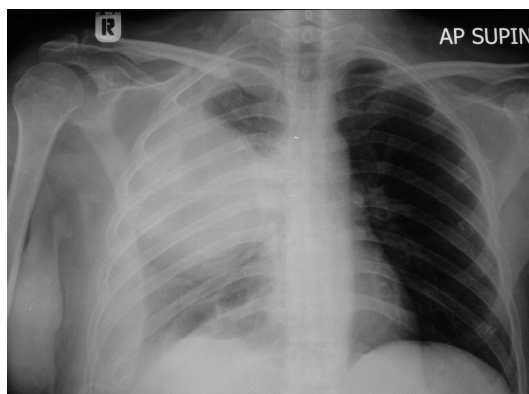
A chest radiograph showing a right sided pleural effusion with a mass in the right hilar area.
